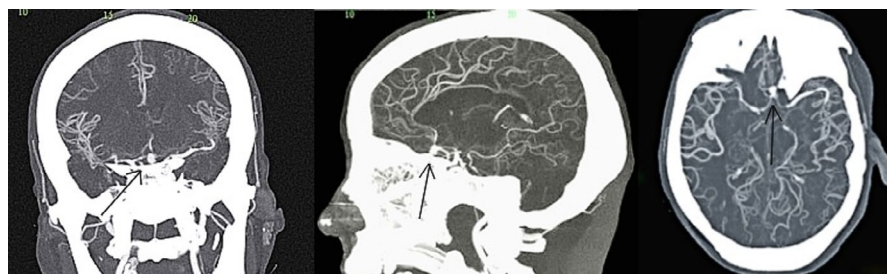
CT Cerebral Angiogram (Coronal/Sagittal/Axial view) demonstrating the ACOM aneurysm (arrow)
